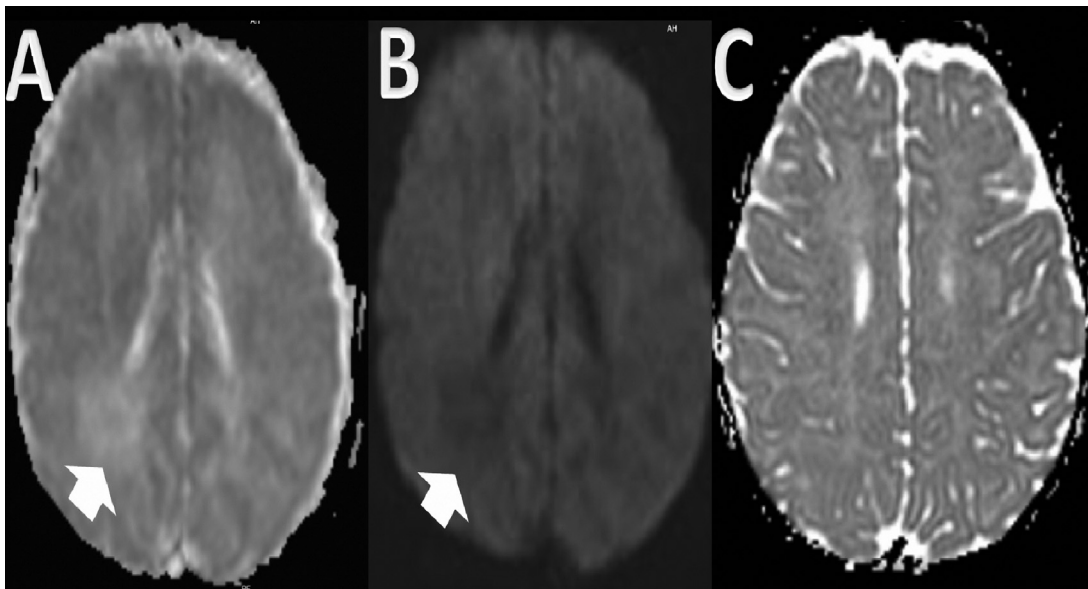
Magnetic Resonance images of the neonate with the suspicion of stroke. A. Axial Apparent diffusion coefficient (ADC) Magnetic Resonance Diffusion-weighted image showing partial restricted diffusion in the right parietal lobe adjacent to the occipital horn of the lateral ventricle, consistent with chronic ischemic hemorrhage (arrow). B. Axial T1-weighted Magnetic Resonance images showing approximately 16 × 16 mm in size, heterogeneous hypointense lesion with blurred borders in the right parietal lobe adjacent to the occipital horn of the lateral ventricle, consistent with chronic ischemic hemorrhage (arrow). C. The control Axial Apparent diffusion coefficient (ADC) Magnetic Resonance Diffusion-weighted image was normal at 7 months of age.
